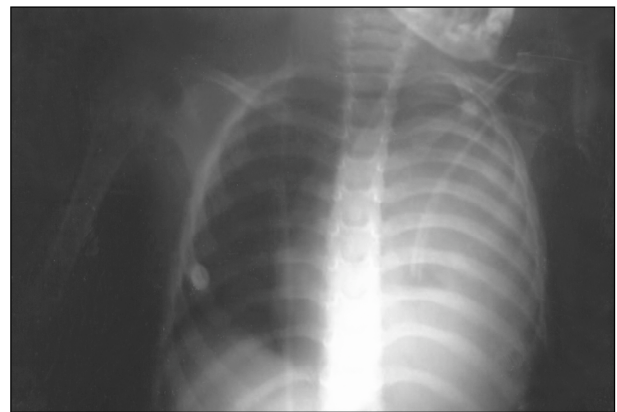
Chest x-ray showing left hemithorax.
